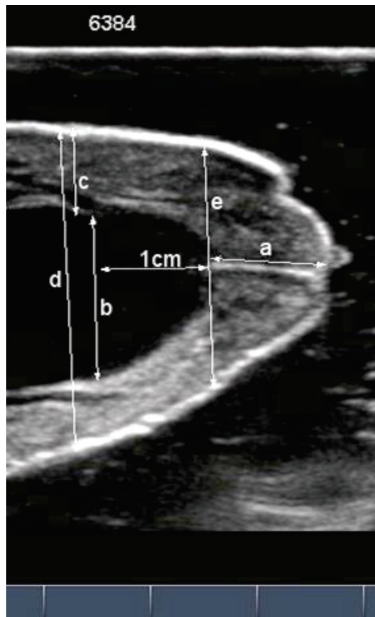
Ultrasound image of a normal teat
